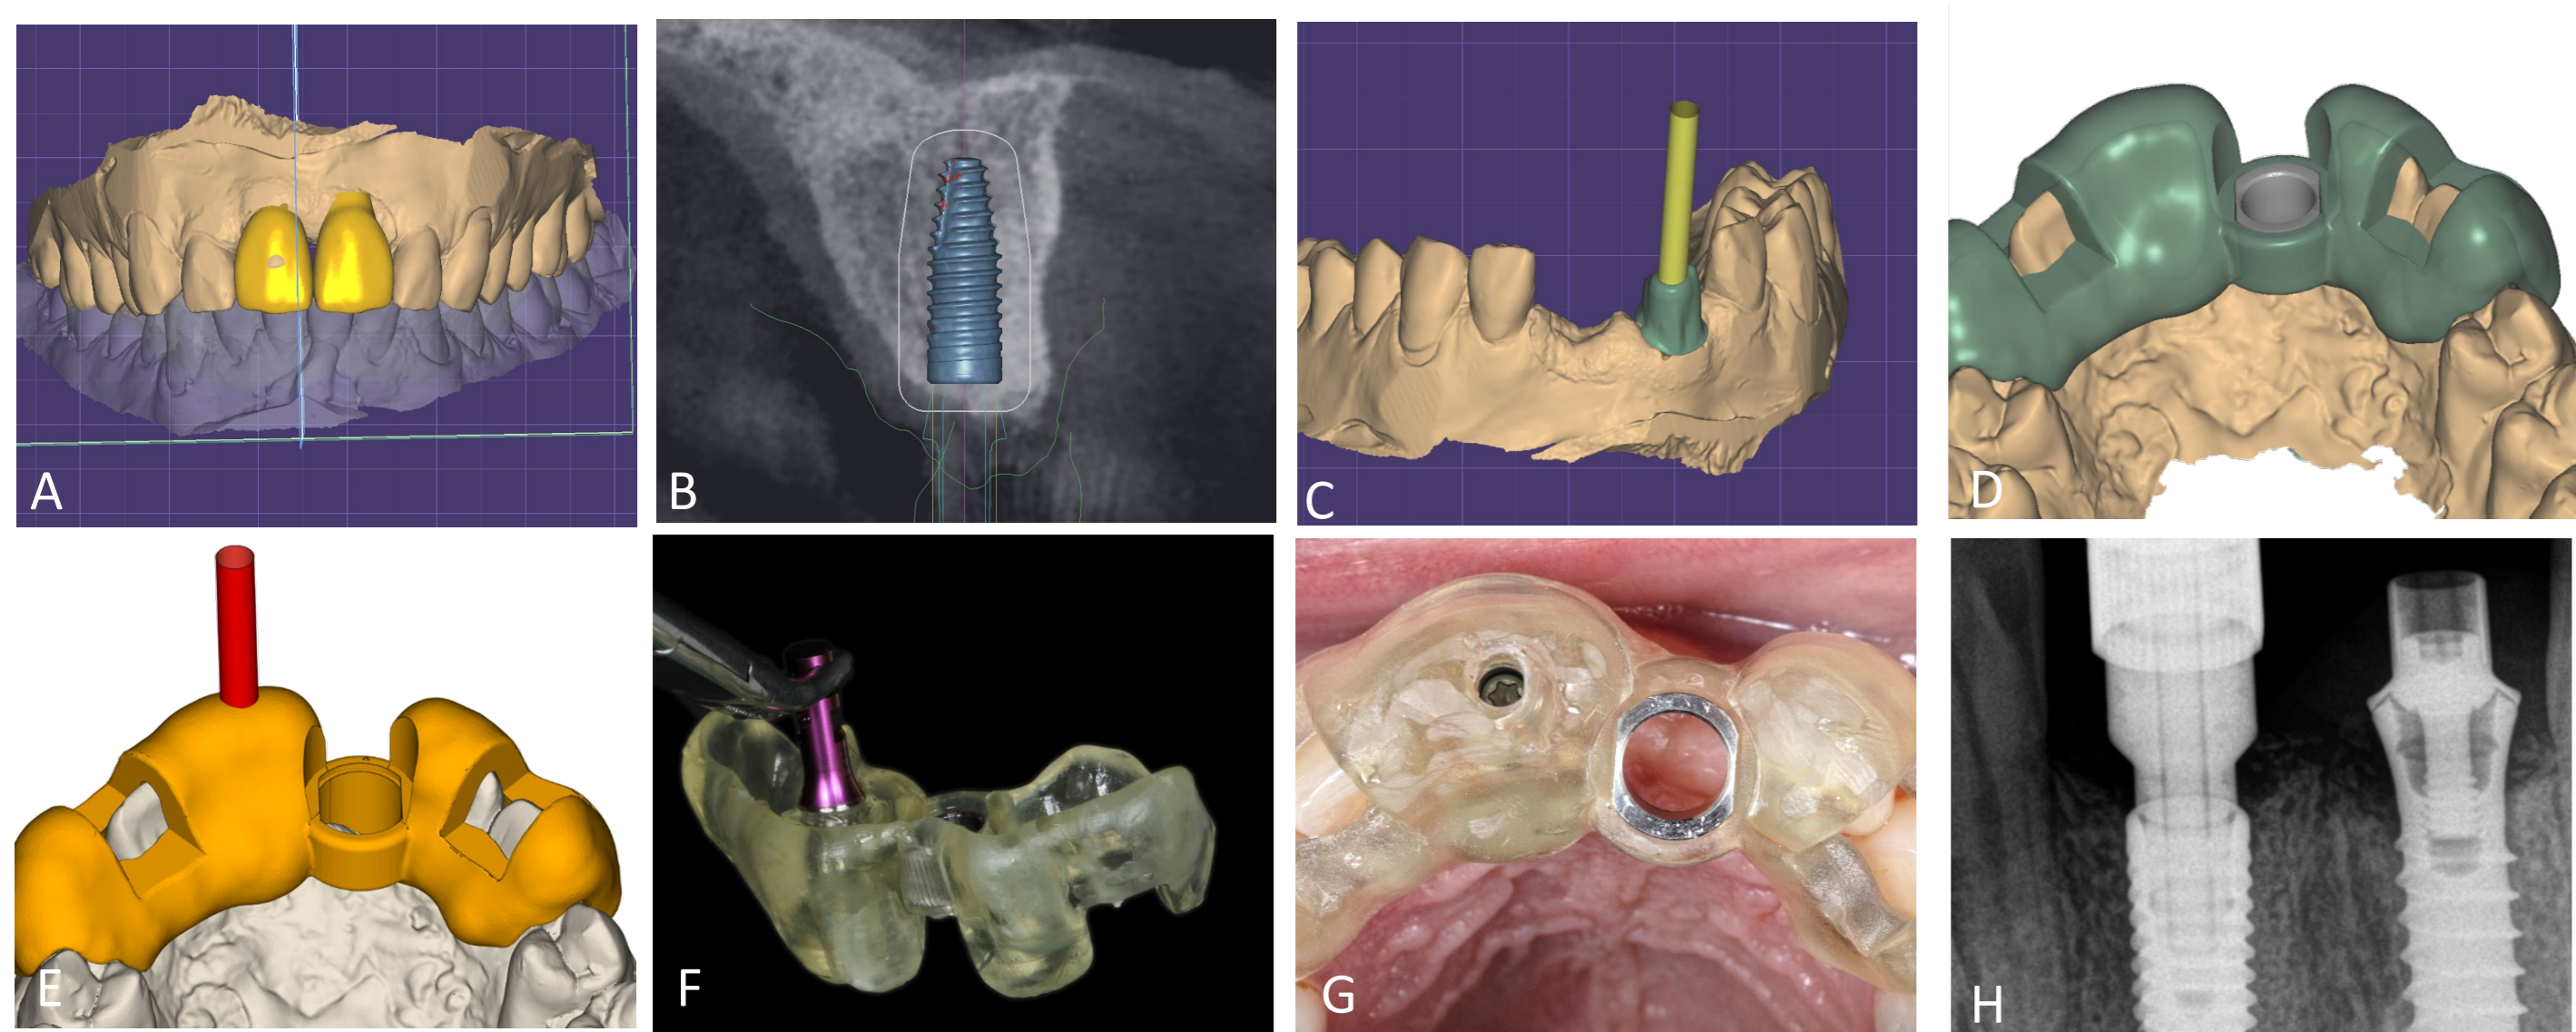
A) Virtual wax up, B) Virtual implant planning, C) crown design, D) Surgical guide design E) Merge with virtual crown, F) Printed surgical guide, G) View of the surgical guide in situ H) periapical radiography of implant placement
